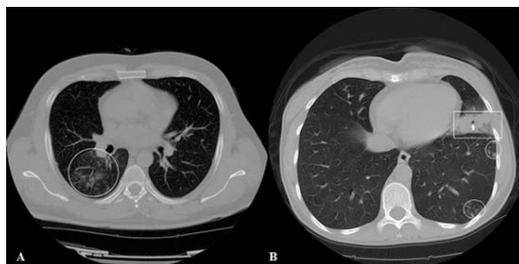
Axial CT image of a 32-year-old male patient shows diffuse localized GGO in the right lower lobe (oblique circle) which is compatible with the "indeterminate appearance".
